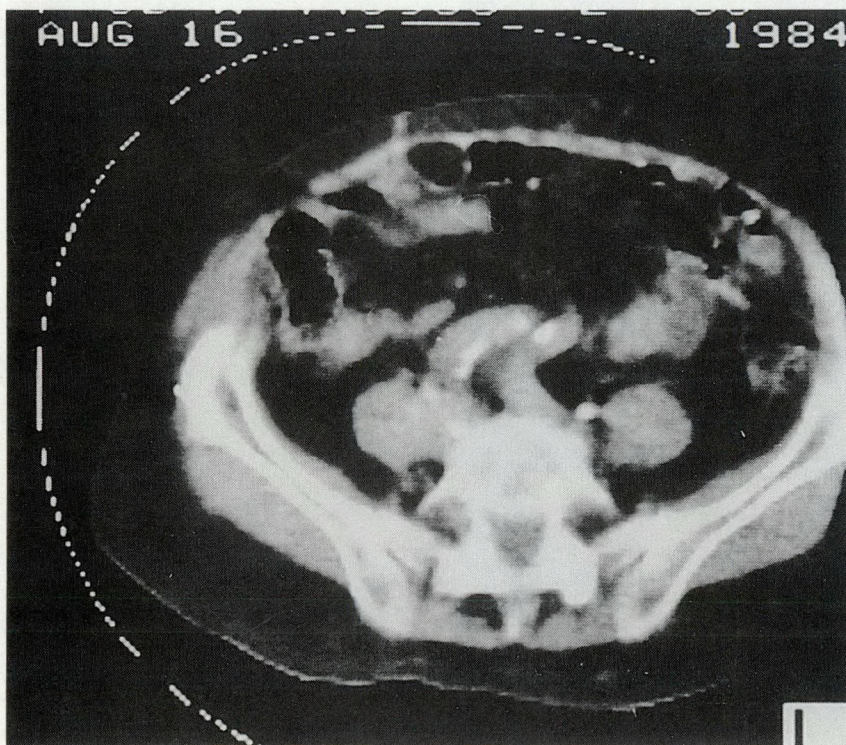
Preoperative computed tomography scan of common iliac arteries.
